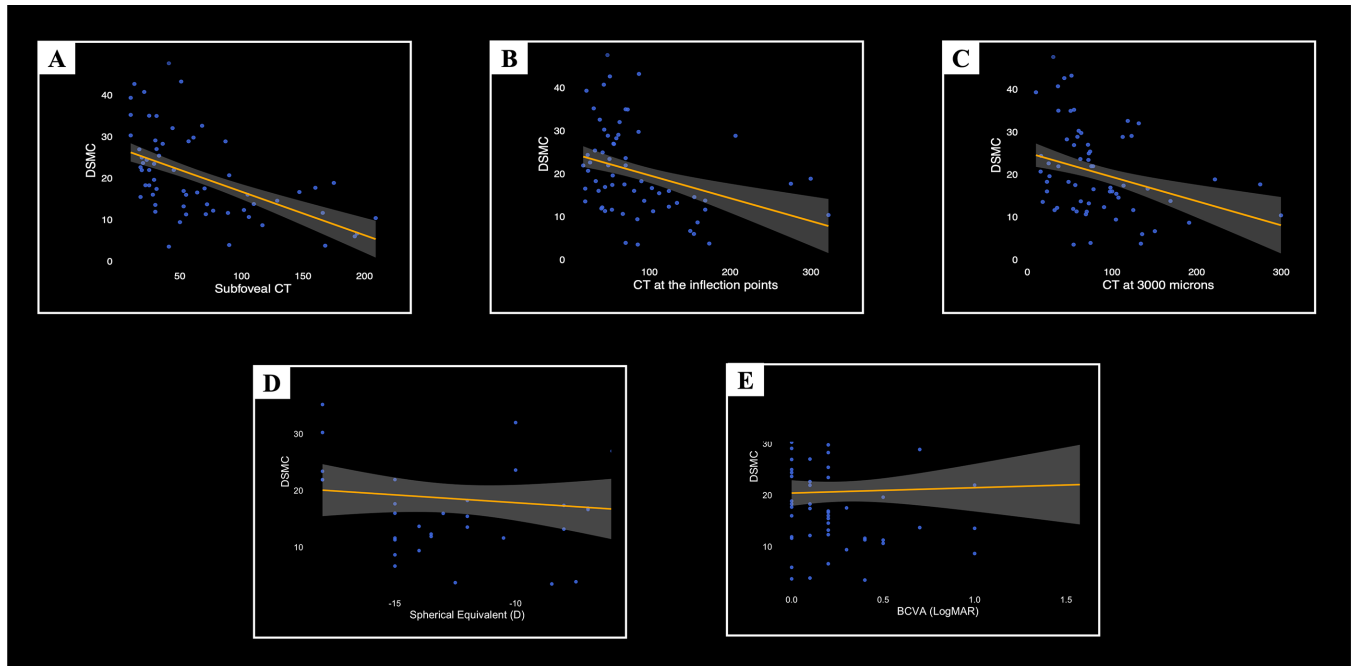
LMM analyses examining the relationships between DSMC and key structural and functional parameters in DSM. (A–C) Significant inverse relationships between DSMC and CT values at the subfoveal level, the inflection points, and 3000 μm from the fovea, respectively. (D, E) Associations of DSMC with SE and BCVA, the latter expressed in logMAR values.
